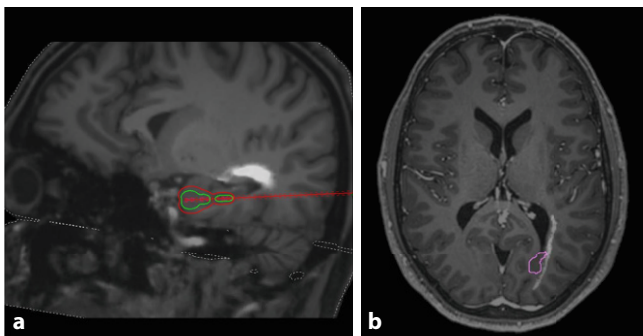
▲ Relevance of visual system imaging in clinical routines. a Presurgical planning for LiTT on T1-weighted image in pseudo-sagittal view. Stereotactic trajectory (red line) and the aimed for lesion zone depicted by a brachytherapy planning tool (arbitrarily chosen: red contour resembles 50 Gy Isodose as desired limit of the irreversible damage zone, green contour resembles 100 Gy Isodose as core heat zone which needs to be monitored for peak temperatures). Neither trajectory nor lesion zone interfere with the visual tract (as defined by deterministic tractography; white area above trajectory), thus minimizing the risk of visual field loss. b Periventricular heterotopia (pink contour) adjacent to superimposed optic radiation (as defined by deterministic tractography; white streak adjacent to the pink contour) on T1-weighted image with gadolinium contrast. (Image courtesy of Dept. for Stereotactic Neurosurgery/Otto von Guericke University Magdeburg)
